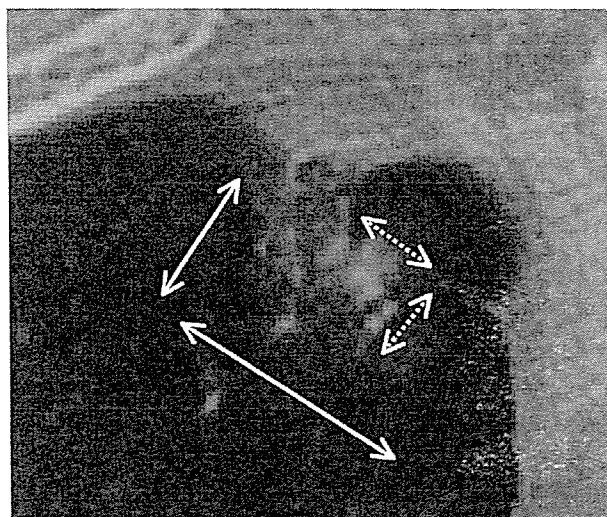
Thin section computed tomographic scan of lung cancer depicting solid attenuation and ground-glass opacity (GGO). The largest area of tumor (solid line) and solid attenuation (dotted line) were decided based on this film. The proportion of GGO area to the entire tumor was defined; $GGO\ ratio = (maximum\ GGO - maximum\ consolidation) / maximum\ GGO$. Max GGO (solid arrow); Max consolidation (dotted arrow).
